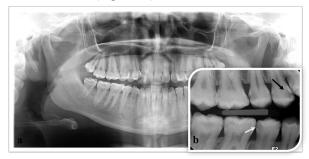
a: *Panoramic image of the patient with bitewing radiographs in the figüre b: Right posterior bitewing radiograph, black arrow;*
